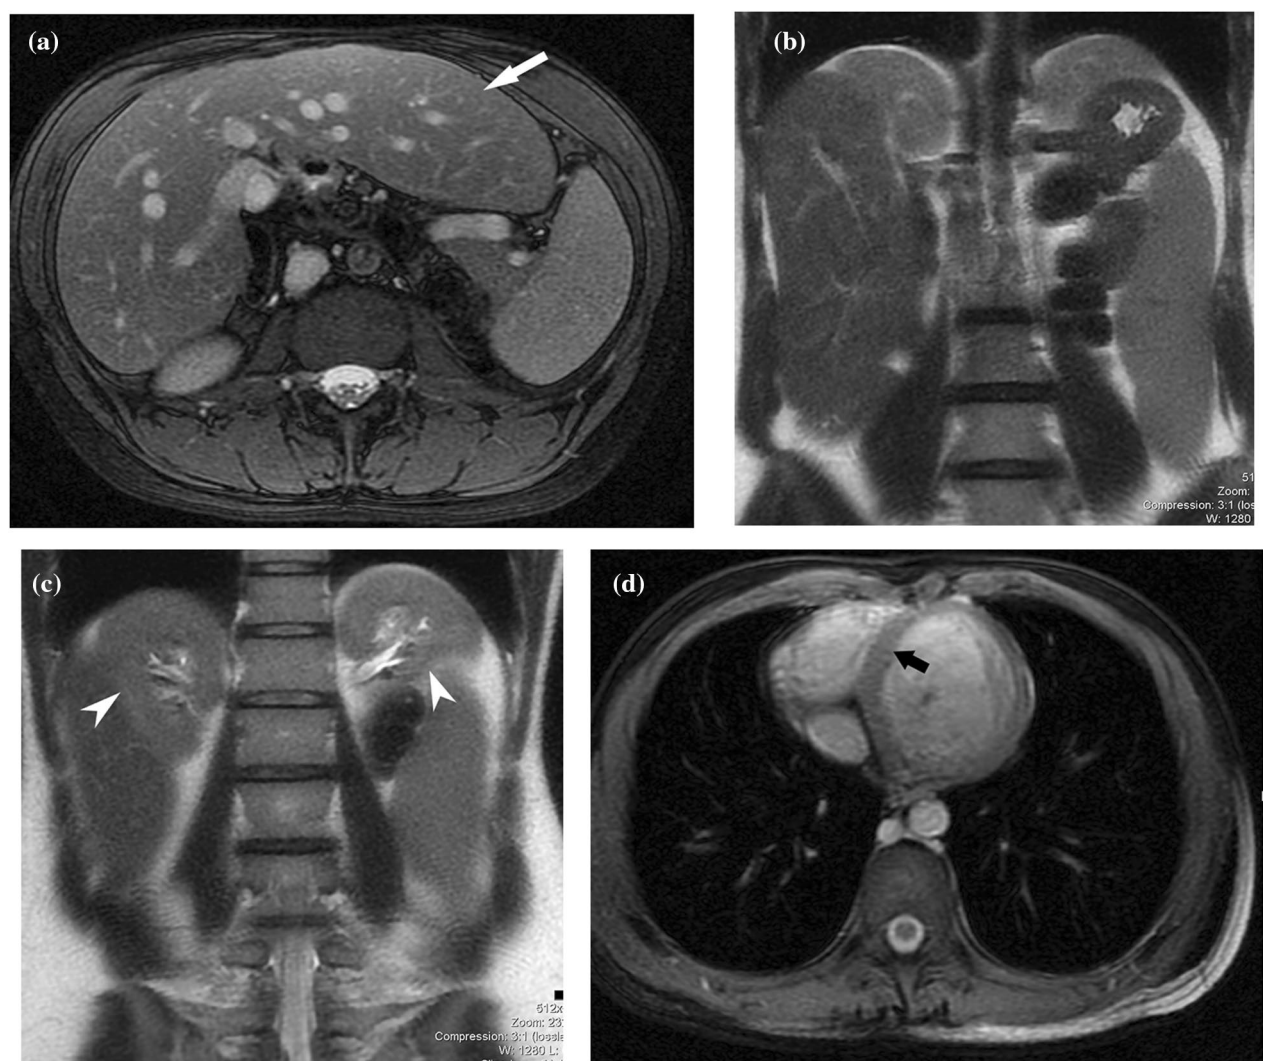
a Axial T2-weighted fat-saturated MRI of abdomen showing abnormally enlarged left lobe of liver crossing midline (white solid arrow), b coronal T2-weighted MRI of abdomen showing enlarged spleen, c coronal T2-weighted MRI of abdomen showing bilateral subdiaphragmatic kidneys (white arrowheads), d axial T2-weighted MRI of abdomen showing interventricular septum (black arrow) and cardiac apex in midline directed anteriorly suggestive of mesocardia
